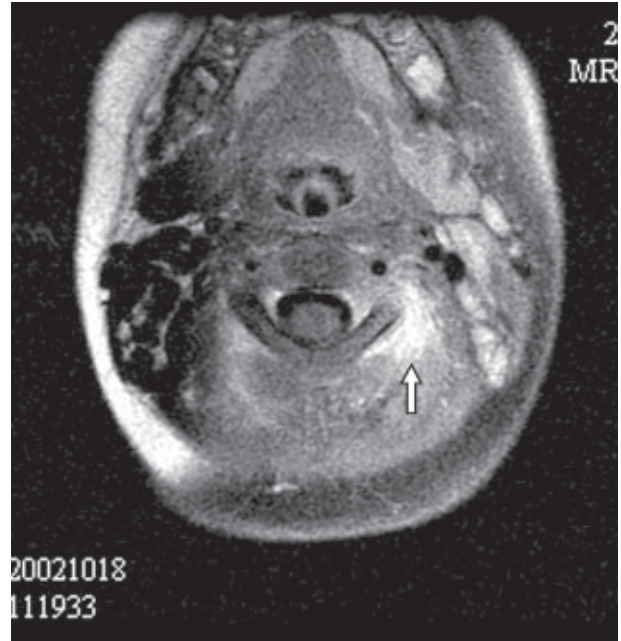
Axial T1-weighted magnetic resonance imaging at the C2 level with fat signal suppression and after intravenous gadolinium-diethylenetriamine pentaacetic acid administration shows abnormal enhancement in the left paravertebral space (arrow).
